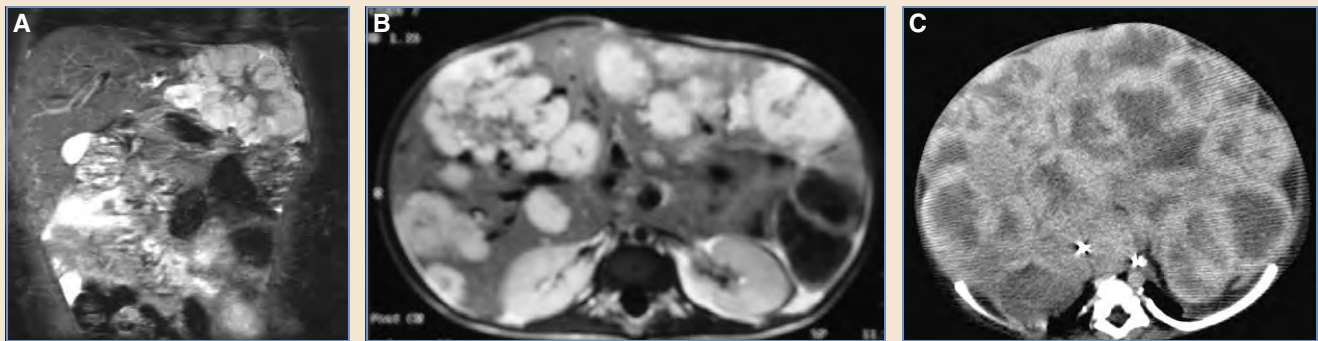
IHH. The three types of IHH are shown: A, Focal. B, Multifocal. C, Diffuse. A and B are T2-weighted MRI sequences, whereas C is a postcontrast CT scan.
